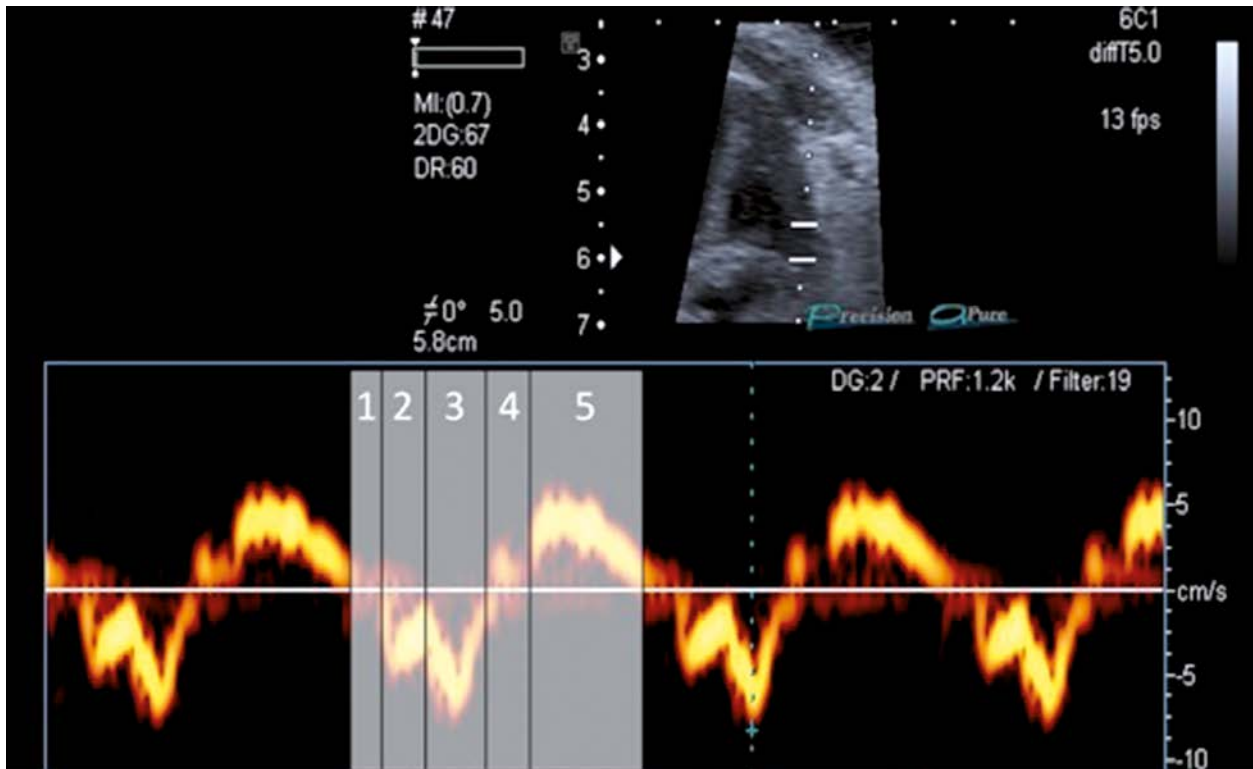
Cardiac cycle in pulsed wave tissue Doppler imaging. The sample volume is placed in the lateral wall of the ventricle. 1 – isovolumetric relaxation time, 2 – E-wave, 3 – A-wave, 4 – isovolumetric contraction time, 5 – ejection time
